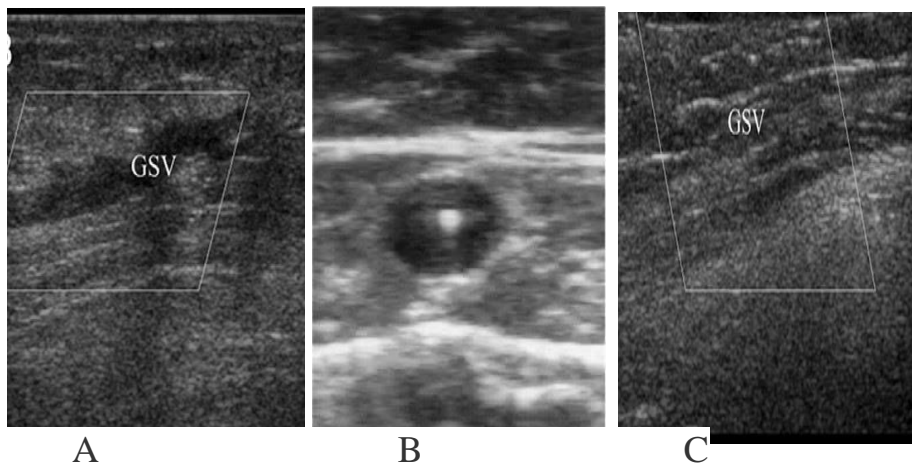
Ultrasound pictures of the great saphenous vein (GSV), A) perioperatively dilated vein. B) the micro-wave catheter inside GSV before treatment. C) post-operative obliterated GSV.
